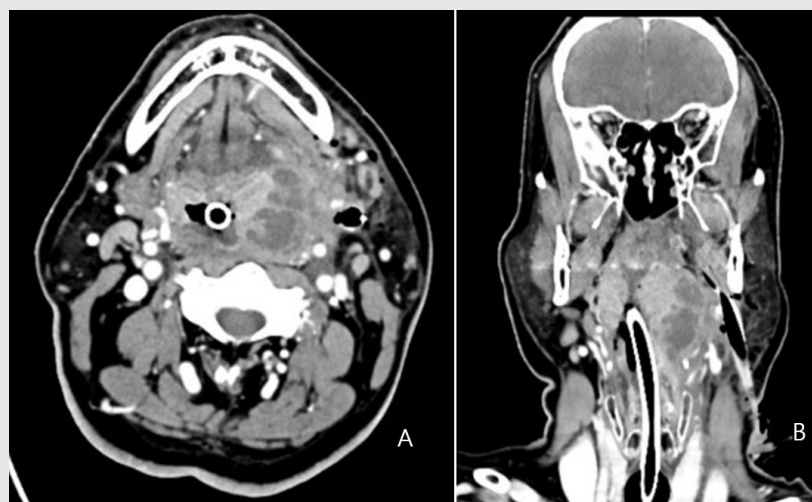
A. Axial view of CT. An increased edema and abscess cavity in the left pharynx. The drainage tube does not enter the abscess cavity. B. Coronal view of CT. The drainage tube only enters the parapharyngeal space and there is no pus collection in the parapharyngeal space.
